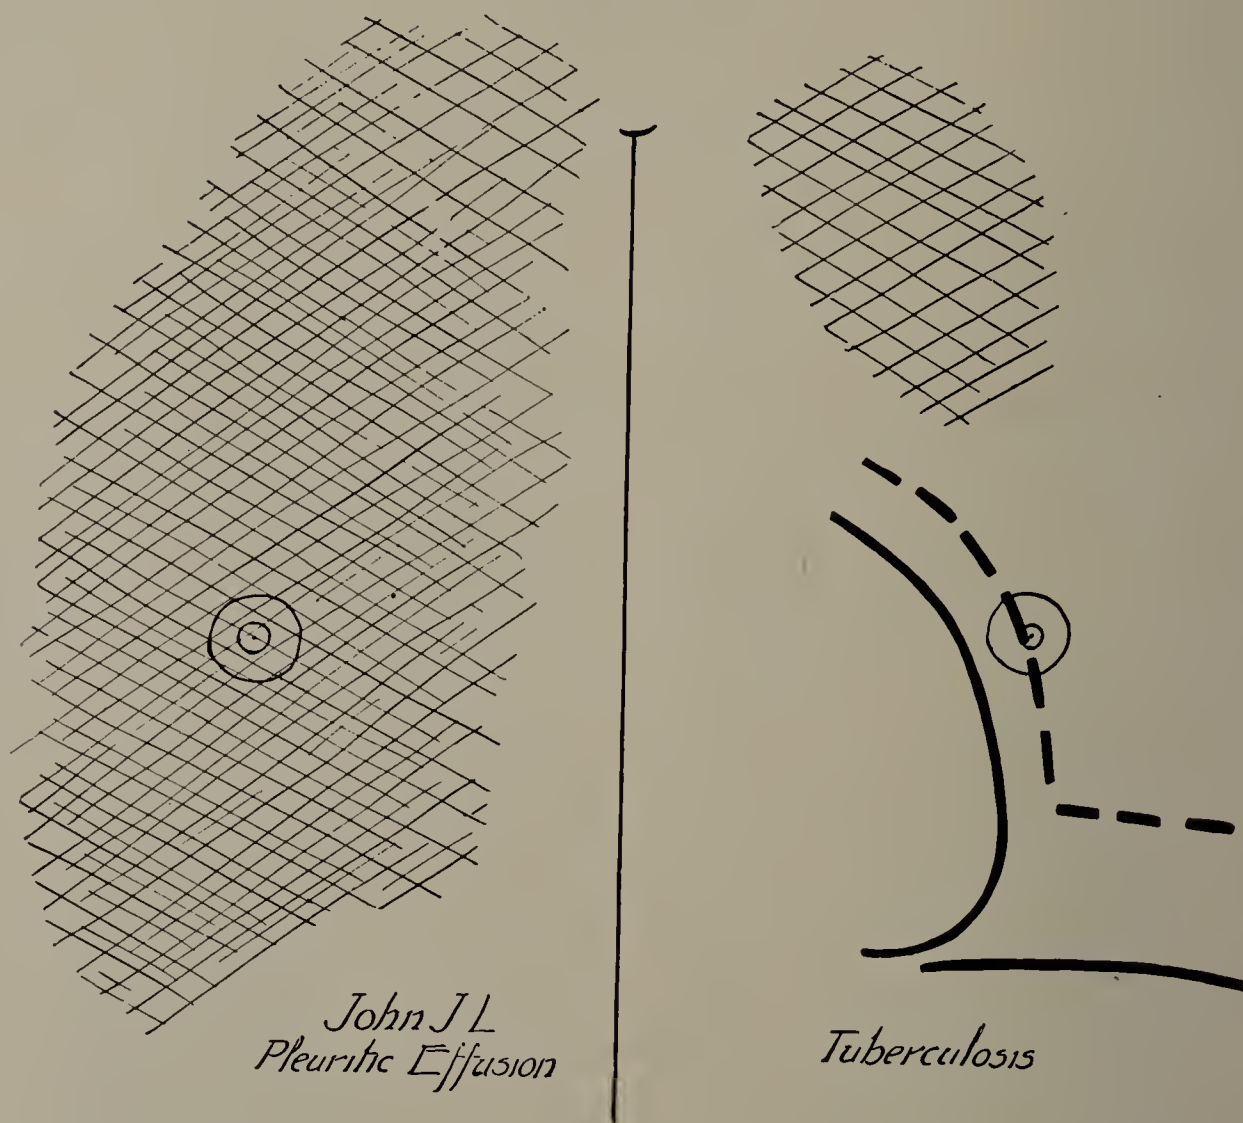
John J. L. May 29, 1899. Cut of X-ray tracing (one-third life size). Pleurisy with effusion on the right side. Heart displaced to left. Shaded left apex shows a tuberculous area.
